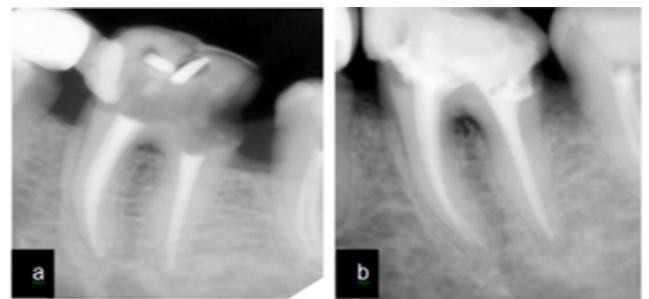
Radiograph taken before luting of fiber post; a: Radiograph taken before luting of fiber post (b).
